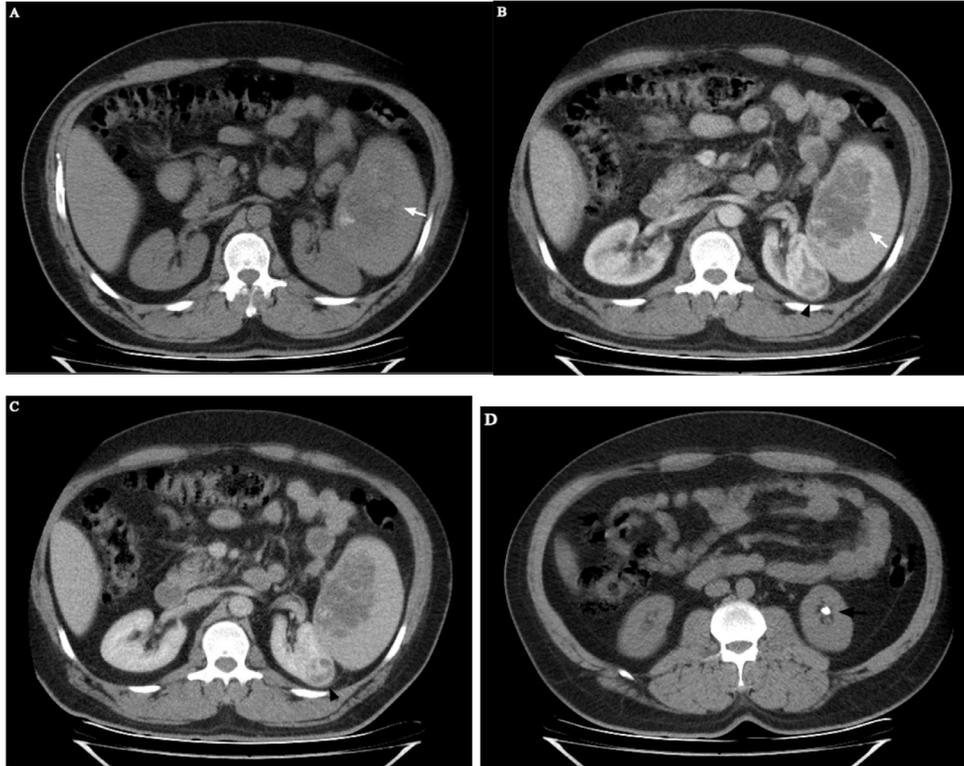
Triphasic abdominal CT in pre-contrast (A, D), arterial (B) and portal (C) phases at the level of the spleen: A 9 × 6.6 × 8 cm (AP × TR × CC) irregularly marginated splenic hilar lesion (white arrows) seen. It is only faintly visualized in the precontrast (A) phase, but shows circumferential rim enhancement and some dispersed central enhancing regions in the arterial phase (B) which subsequently fade in the portal phase (C). On the same planes, there is a 2.8 × 3 × 3.5 cm (AP × TR × CC) left posterosuperior relatively well-defined round or ball shaped renal contour deforming and heterogeneously enhancing renal mass (black arrowheads). Incidental note is made of a small left lower pole stone without causing calyceal dilation (black arrow D).
